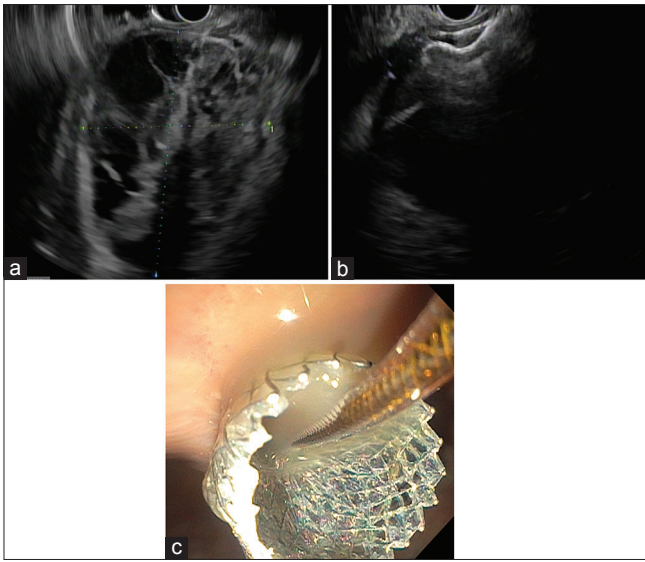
(a) Endosonographic visualization to identify a pancreatic fluid collection, (b) endosonographic visualization of the distal flange of the lumen-apposing metal stents deployed within the pancreatic fluid collection, (c) endoscopic visualization of the proximal flange deployed within the stomach
